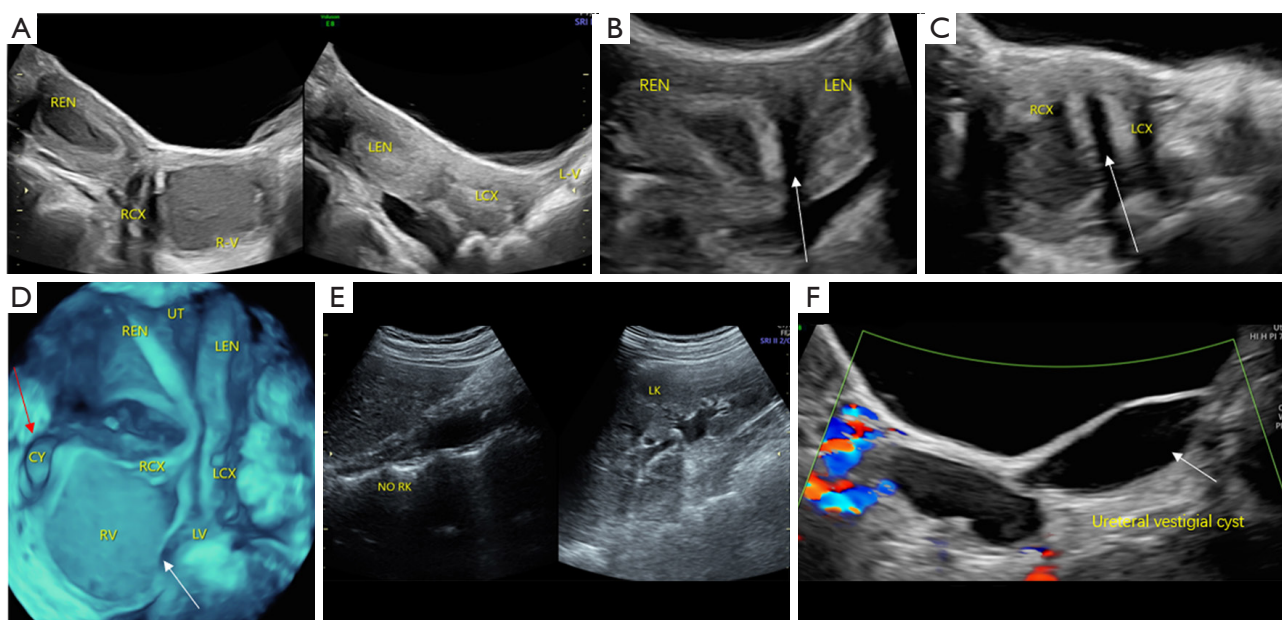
Type I-b UGTOIRA syndrome: U2b-C1-middle OVS, complete septal uterus, septate cervix without cervical obstruction, with right-middle OVS (with a foramen on the OVS observed intraoperatively), and right renal agenesis with right ureteral vestigial cyst. Sonograms were obtained from a 13-year-old female patient. (A) TAS 2D sagittal pelvic planes demonstrating a hemorrhage in the right uterine cavity, cervical canal and the posterior space of the OVS (left side of the figure), normal left uterus, cervix, and left vagina (right side of the figure). (B) TAS 2D coronal section of the uterus demonstrating complete septal uterus (the arrow indicates the septate). (C) TAS 2D cross-section of the cervix demonstrating a septate cervix (the arrow indicates the septate). (D) TAS 3D coronal plane of the uterus-cervix-vagina under stereoscopy demonstrating the complete septal uterus, septate cervix, middle OVS with a medium amount of hematocele in the posterior space of the OVS (the white arrow indicates the OVS), and a ureteral vestigial cyst (the red arrow indicates the cyst), which connected with the right wall of the vaginal vault. (E) TAS 2D sagittal planes identifying the absence of the right kidney (NO RK; left side of the figure) and a normal left kidney (LK; right side of the figure). (F) TAS 2D sagittal plane demonstrating a ureteral vestigial cyst that connected with the trigone of the bladder and the right wall of the vaginal vault (the arrow indicates the ureteral vestigial cyst). REN, right endometrium; RCX, right cervix; RV, right vagina; LCX, left cervix; LV, left vagina; LEN, left endometrium; UT, uterus; CY, cyst; RK, right kidney; LK, left kidney; UGTOIRA, unilateral genital tract obstruction with ipsilateral renal anomaly; OVS, oblique vaginal septum; TAS, transabdominal sonography; 2D, 2-dimensional; 3D, 3-dimensional.
